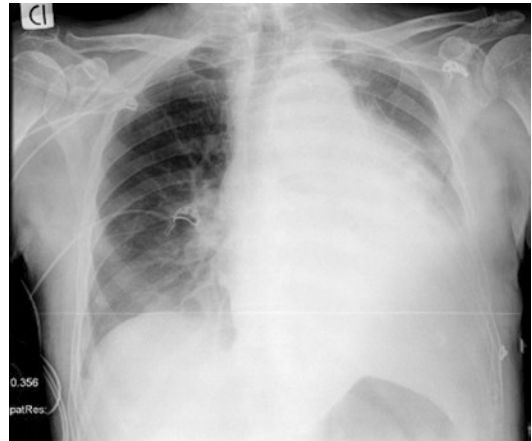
Chest X-ray (CXR) in blunt thoracic trauma shows widened mediastinum, abnormal aortic contour, loss of the aortopulmonary window, left-sided pleural effusion, and pulmonary contusion
